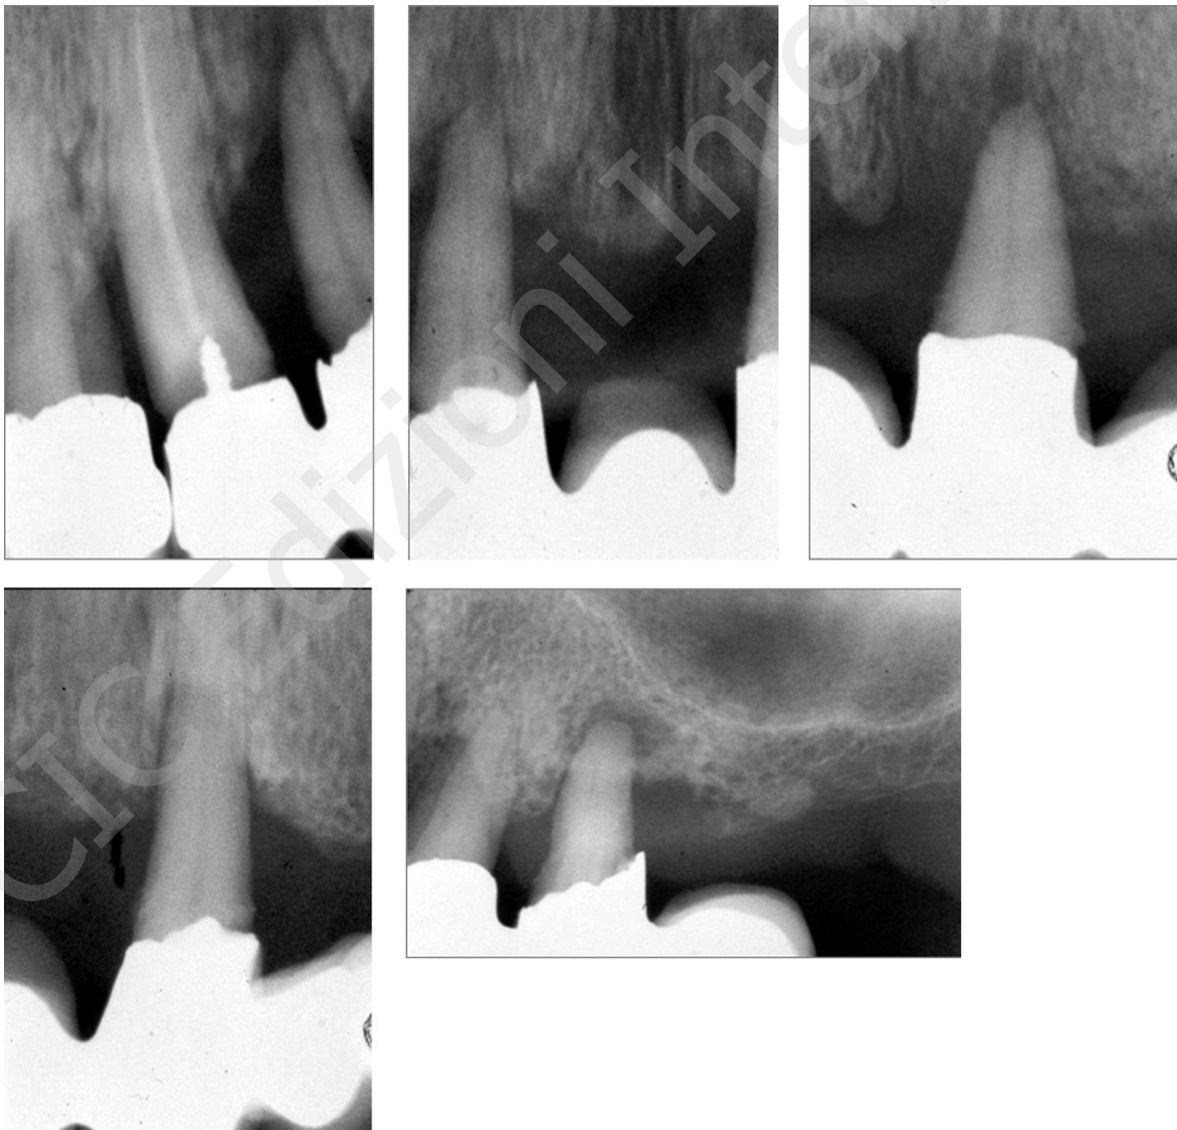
Radiographic evaluation of the residual teeth.
